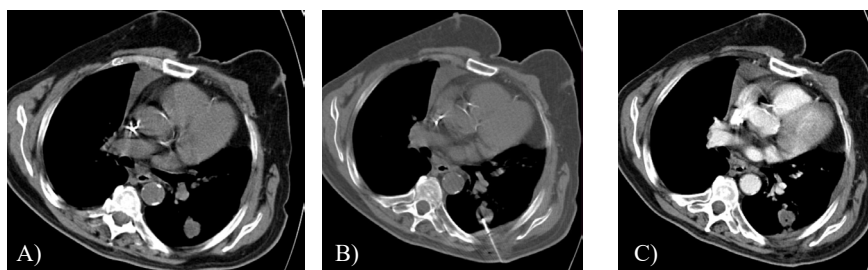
Axial computed tomography images of a male patient with non-small cell lung cancer of the inferior lobe of the left lung, treated with microwave ablation (MWA). A) Tumor lesion on computed tomography before MWA; B) the microwave antenna punctured the lesion; C) follow-up computed tomography immediately after MWA reveals imaging of the lesion as hypodense without contrast enhancement.
